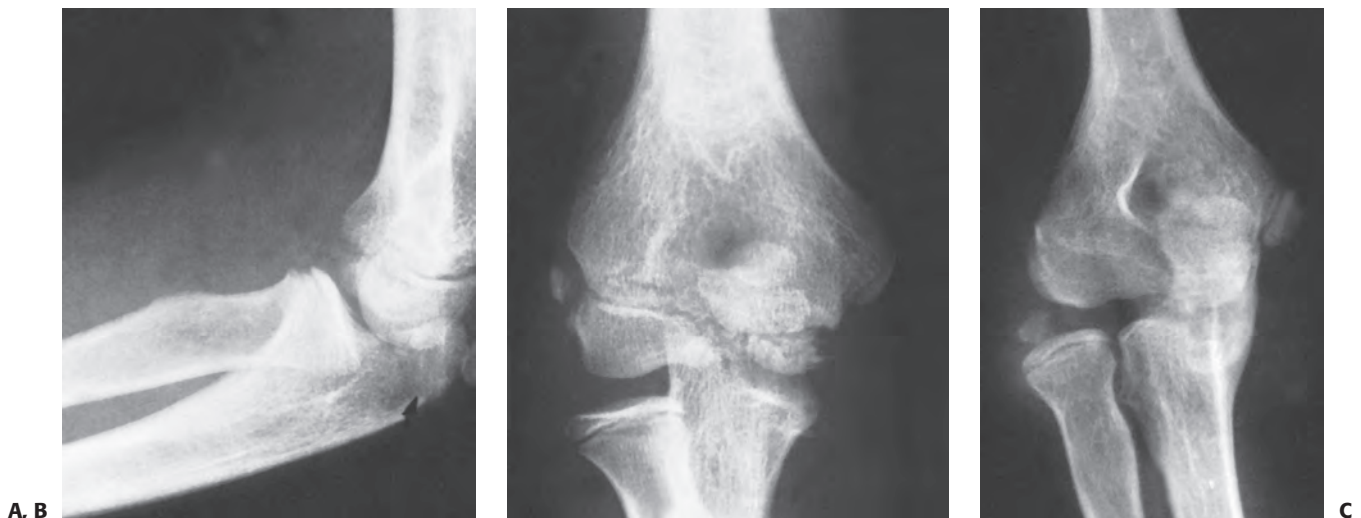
Loss of reduction. A: Lateral radiograph of what appeared to be a simple undisplaced fracture (*arrow*) of the olecranon in a 13-year-old female. B: On the anteroposterior film, the fracture also appears undisplaced. The mild lateral subluxation of the radial head was not recognized. C: Radiographs taken 5 months later showed further lateral subluxation with resultant incongruity of the elbow joint. (Courtesy of Richard W. Williamson, MD.)
